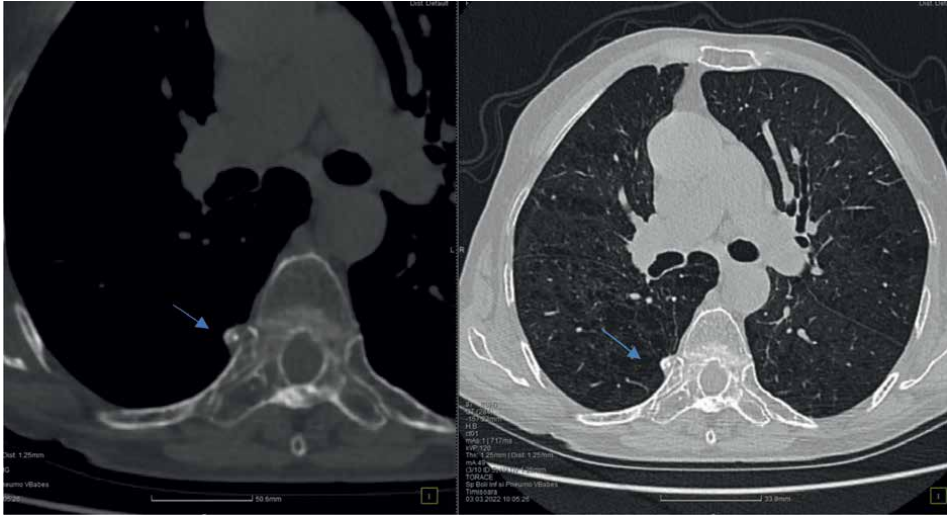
CT images in the axial plane: (left) solitary pulmonary tissue nodule located in the periphery of the right lower lobe, with central calcification—pathognomonic appearance for histoplasmosis; (right) nodular appearance evident on the lung window.
